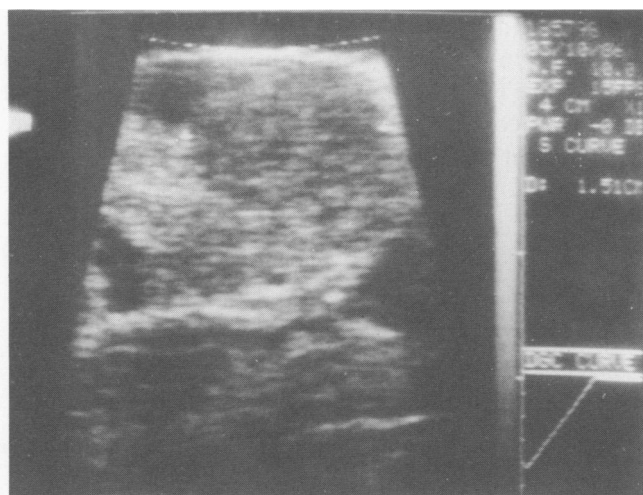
Operative sonographic appearance of an islet cell tumor that was subsequently resected and proven to have malignant features pathologically. The tumor was sonolucent compared to the echogenic surrounding pancreas, but the border of the tumor was not clearly marginated and there was extension into surrounding pancreas. This sonographic appearance was consistent with a malignant islet cell neoplasm.
